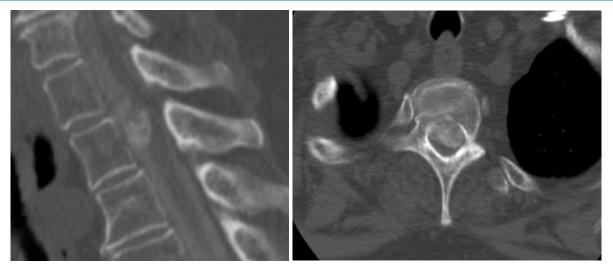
Initial CT myelogram of the thoracic spine prior to first surgical intervention a) sagittal b) axial. Note lack of contrast flow at the ventral aspect of the mass.
